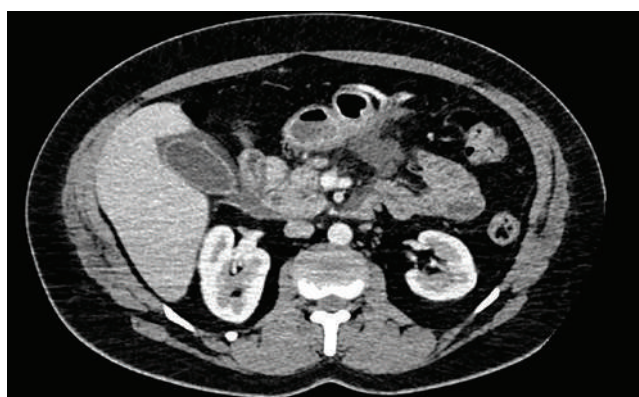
Computed tomography image of the gallbladder and pancreas. Contrast-enhanced CT image showing a hydropic gallbladder with wall thickening and pericholecystic and peripancreatic fluid collection, suggestive of acute cholecystitis and acute pancreatitis.
